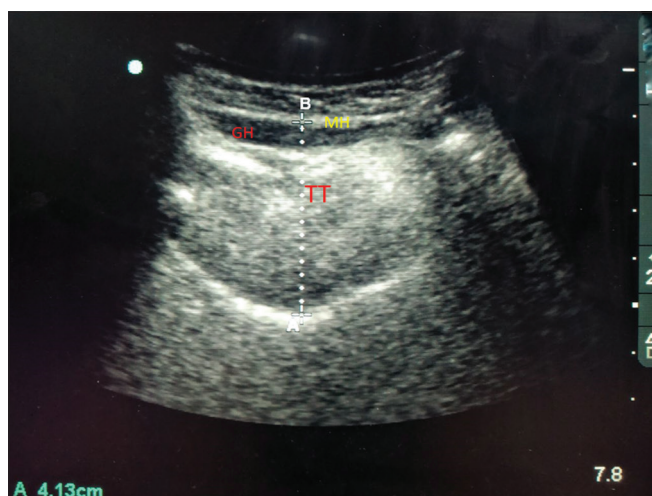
Measurement of TT using ultrasonography. GH = geniohyoid, MH = mylohyoid, TT = tongue thickness (dotted line from a to b)
